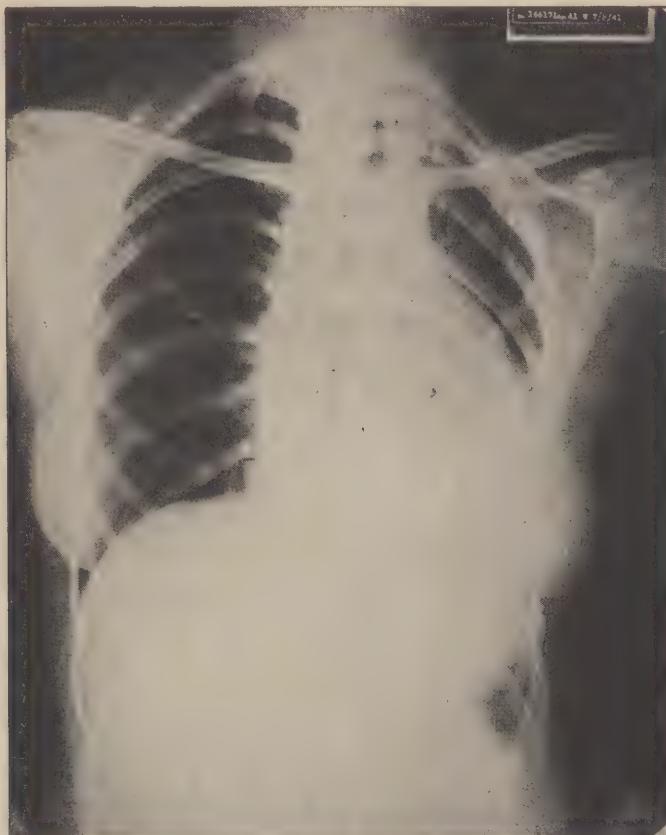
X-ray July 8, 1941 showed atelectasis of the lower left lobe and fibroid tuberculosis of the left upper lobe; right lung was normal.
